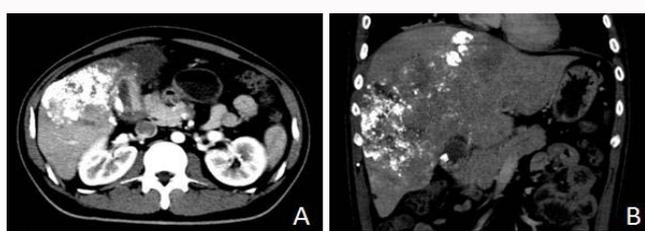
Ischemic cholecystitis (gallbladder lipiodol embolism) occurred in a patient with huge HCC after TACE. (A) CT scan shows the tumor located in liver segment V, closed to gallbladder. (B) Coronal CT imaging in the same patient.
